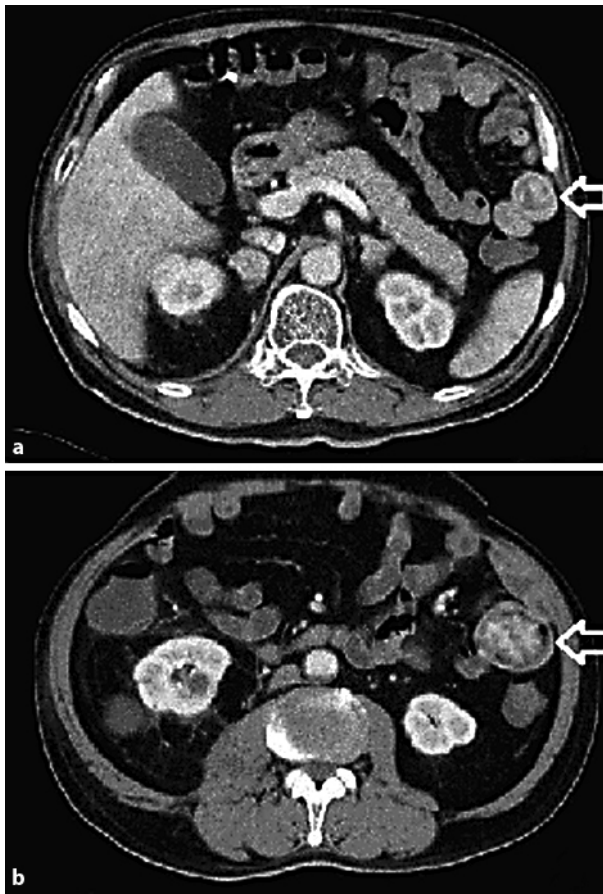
a, b Transverse image of triphasic CT enterography of the small bowel. Note that two enhanced tumors (arrows) suggestive of small bowel metastatic tumors were found in the jejunum.
